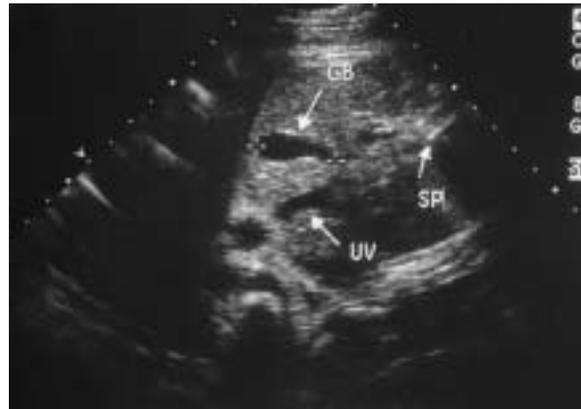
Sonogram of a teardrop-shaped fetal gallbladder in the transverse view of the fetal abdomen. GB = gallbladder; SP = spine; UV = umbilical vein.
